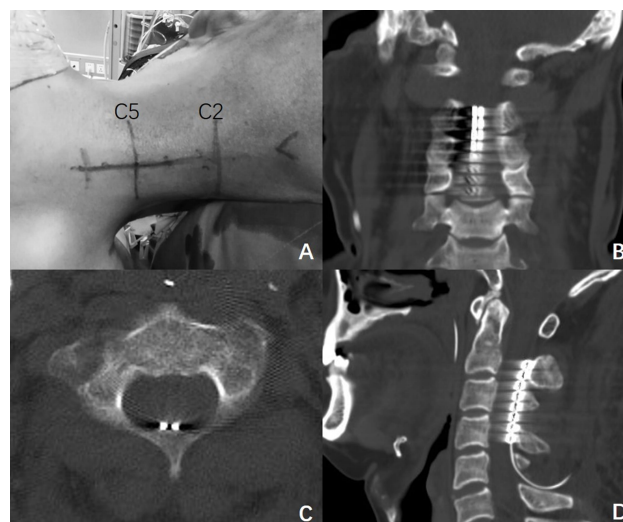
Representative images of the surgical positioning and postoperative computed tomography (CT). (A) A patient in the right decubitus position, with incision markings at the C2-5 spinous processes. (B–D) Representative images of the electrode array in the coronal (B), horizontal (C) (at the most cephalic contact level), and sagittal (D) CT views.
